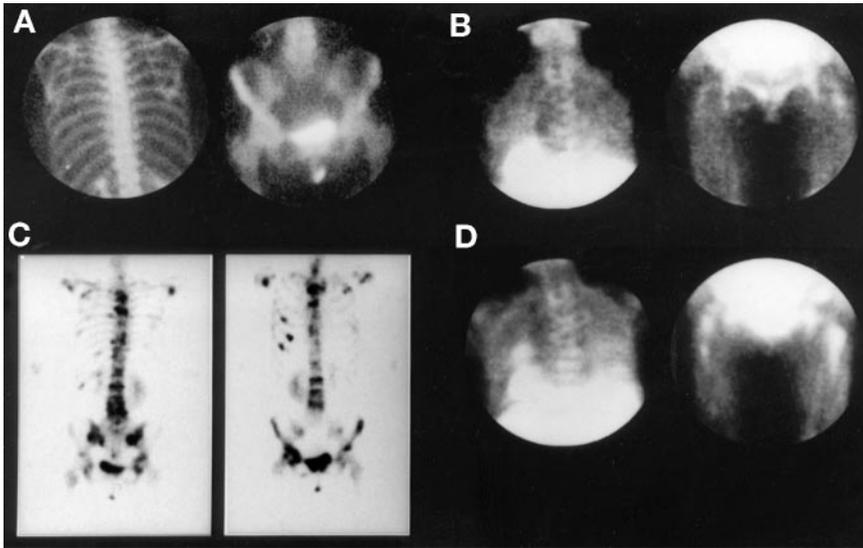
Patient with breast cancer. (A) Initial ^{99m}Tc -HMDP scans show no bone metastases. (B) ^{99m}Tc -MIBI scans show multiple lesions in thoracic spine, bilateral proximal femur, and right pubic bone. Findings were confirmed 1 mo later by MRI. (C) Multiple intense accumulations of ^{99m}Tc -HMDP appeared 4 mo later on whole-body scans. (D) Further ^{99m}Tc -MIBI scans (second set) show increased accumulations in thoracic spine, bilateral proximal femur, and left lung metastatic lesion. ^{99m}Tc -HMDP accumulations in more extensive sites, including bilateral proximal femur, appeared 2 mo after obtaining second set of ^{99m}Tc -HMDP scans.
